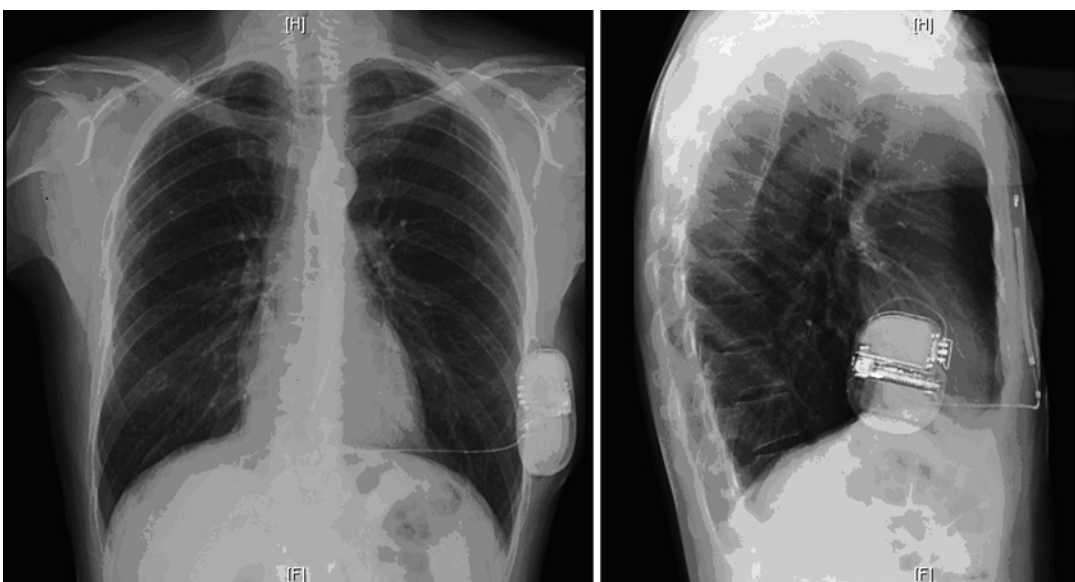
Chest X-ray postimplantation of the S-ICD (posteroanterior and lateral views)
